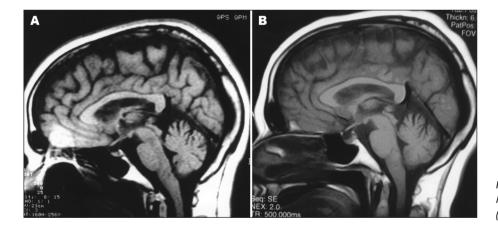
Sagital T1-weighted MRI. [A] Moderate generalized cortical atrophy (1997). [B] Less atrophy in 2007.
